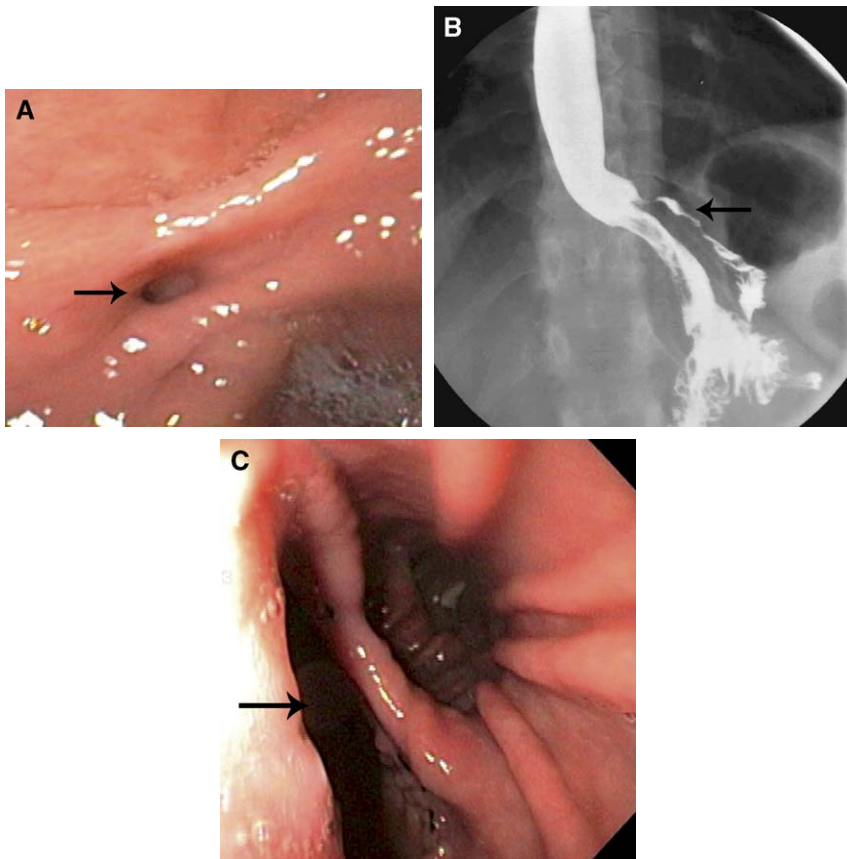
(A) Endoscopic appearance of a small staple line dehiscence after gastric bypass (arrow). (B) Radiographic appearance of staple line dehiscence with gastrogastric fistula (arrow). (C) Endoscopic appearance of a large staple line dehiscence (arrow), allowing easy access to the bypassed stomach.
